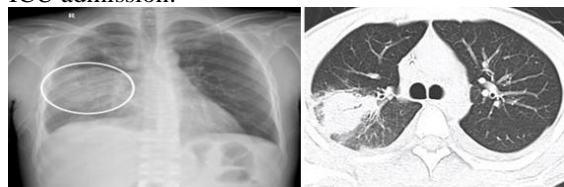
Right lung middle and lower lobe consolidation on CXR and CT chest
